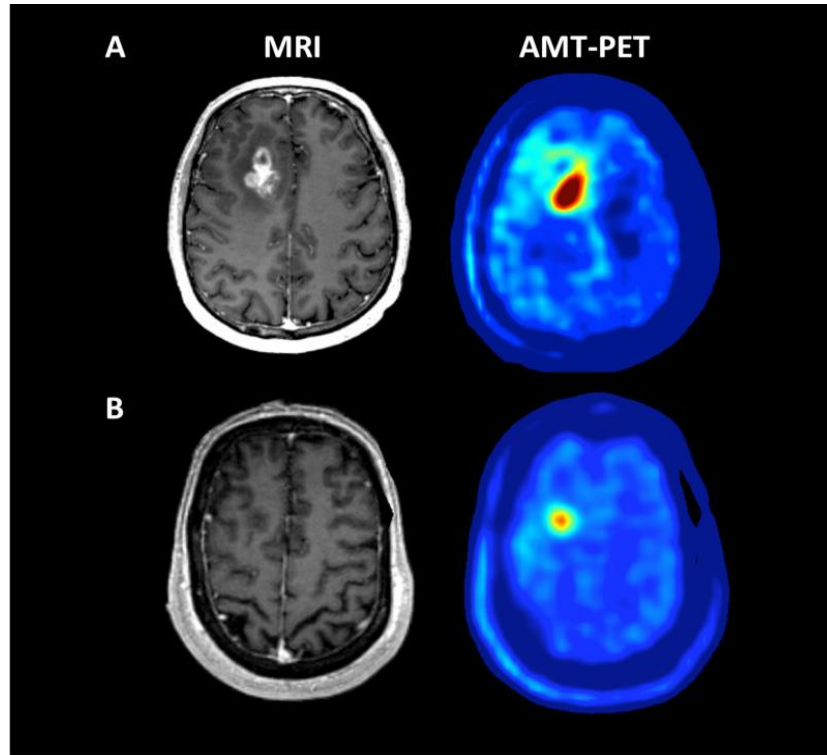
Representative examples of MRI (T1-Gad) and AMT-PET in a patient with high (A) vs. low (B) AMT uptake associated with different survival. (A) A 54 year-old male with a right frontal glioblastoma, measured with a 2.59 tumor/cortex AMT SUV-ratio, above the ROC-defined threshold of 1.94. He survived for more than 2 years after the PET scan. (B) A 68 year-old male with a right frontal glioblastoma showing a below-threshold tumor/cortex AMT SUV-ratio (1.56). He survived for only 7 months.
